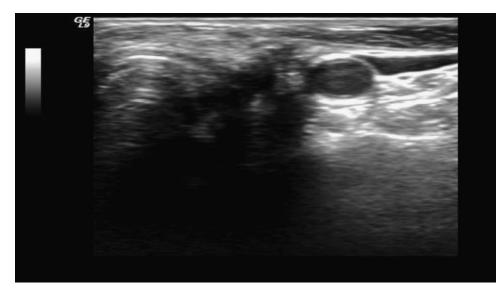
Ultrasound after 20 months of follow-up.
